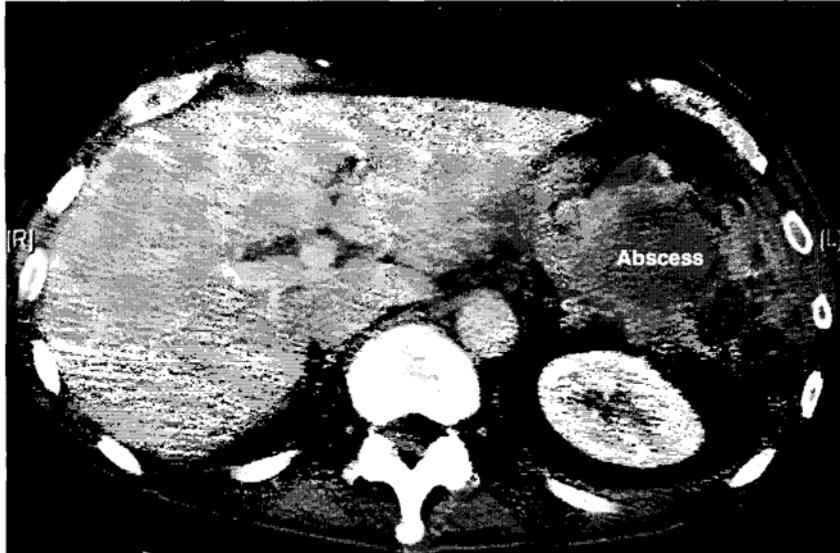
Abdominal CT scan showing a multiloculated abscess in the left upper quadrant in a post-splenectomy patient. (CT image courtesy of the Loyola University Medical Education Network, www.lumen.luc.edu/lumen)
